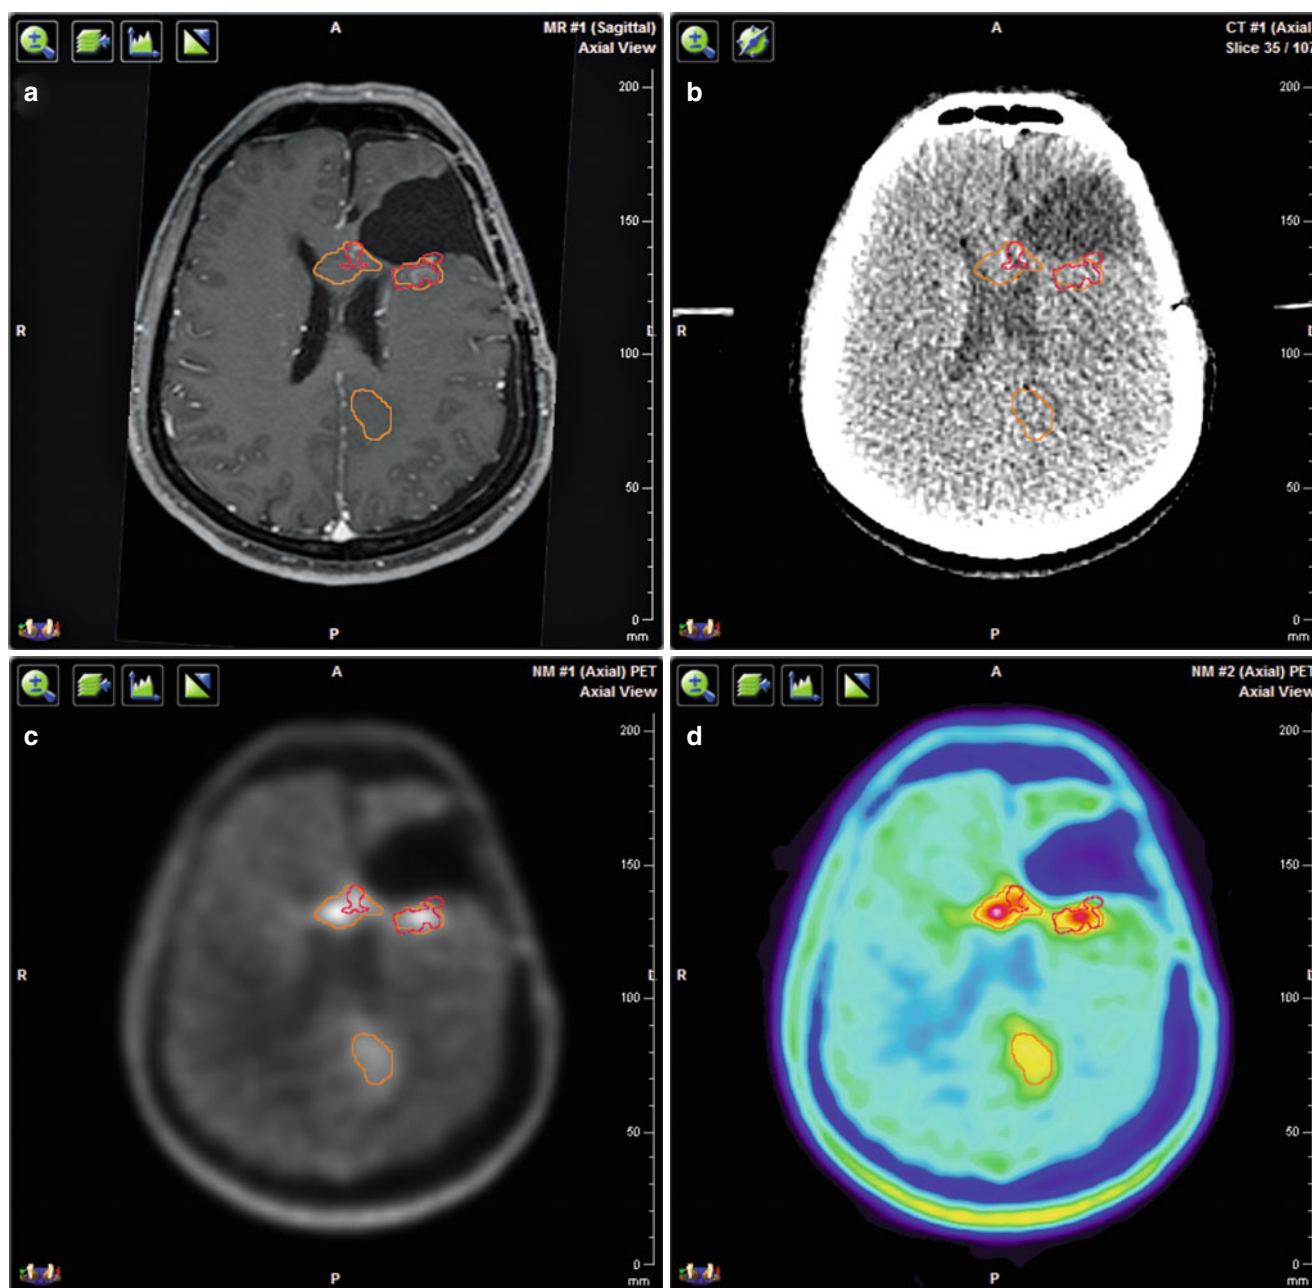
Multimodal imaging for target volume delineation in a patient with recurrent glioblastoma. (a) Three-dimensional T1-weighted contrast enhanced MRI. (b) Planning CT. (c) 18F-FET PET/CT with CT-based attenuation correction in gray scale. (d) 18F-FET PET/CT with CT-based attenuation correction in rainbow scale. All images are
